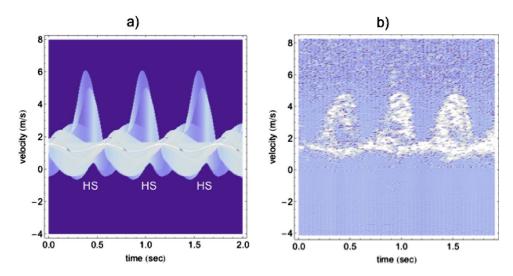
(Color online) (a) Contributions to a Doppler sonar gram from all body segments of an individual walking toward the sonar. (b) Measured data for a scenario similar to that modeled in Fig. 3(a). The height of the individual is 1.89 m and the speed of walking is 1.34 m/s.
